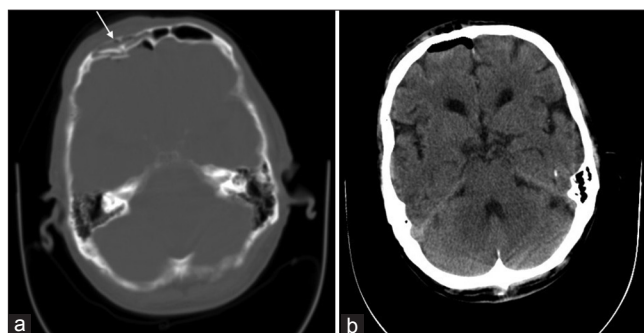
CT scans on patients admitting to hospital: Fracture of frontal sinus and minimal pneumocephalus
